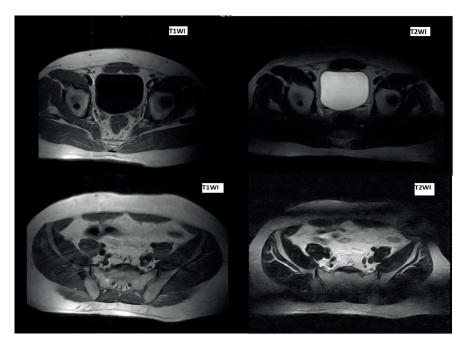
Pelvic MRI (Transaxial slice) showing T1WI and T2WI hypo intense focal lesions in right ilium and acetabulum.
